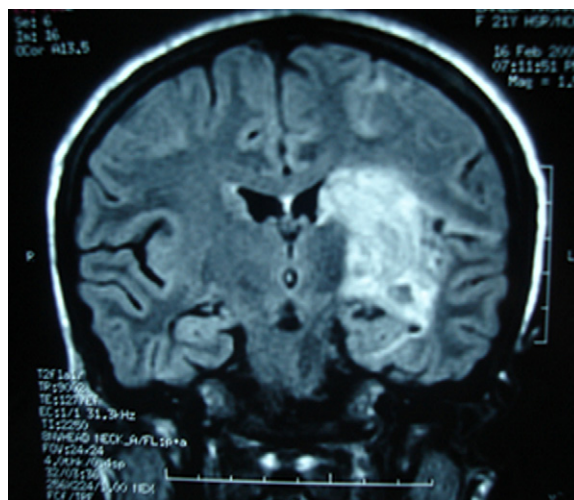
Coronal MRI of the brain: T₂ flow attenuated inversion recovery sequence shows a left paraventricular hyperintense lesion, indicative of ischemic stroke with hemorrhage and edema in the deep territory of left MCA.
